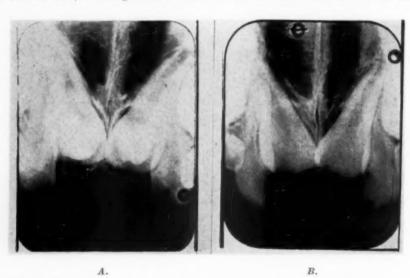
A, X-ray of a boy of 10 years showing two dentigerous cysts in formation, retaining two suupernumerary teeth which cause the noneruption of the central incisors. B, The same boy after removal of cysts with the two supernumerary teeth.
